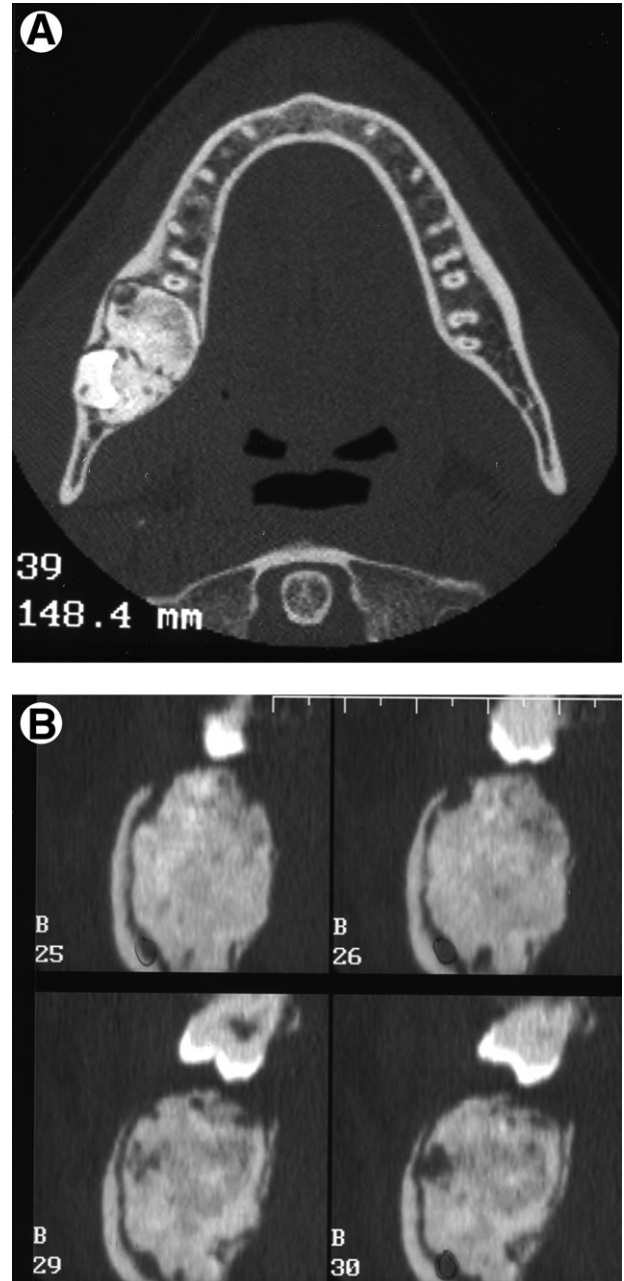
Axial CT (A) showed a radiopaque lesion located in the third molar region with bone expansion and thinning of the cortices. (B) Denta Scan shows the exact location of the inferior dental nerve in relation to the lesion.
